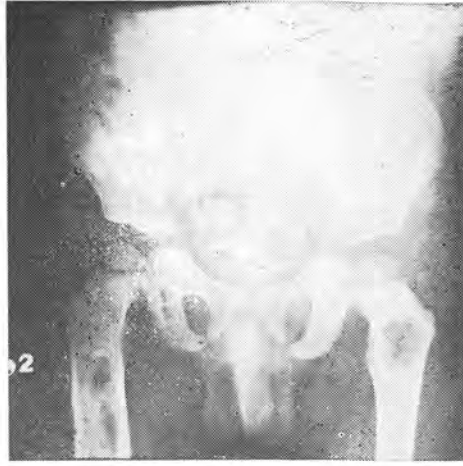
X-ray photos of the pelvic bone, showing the osteolytic lesions (left) which diminished in size after therapy was instituted (right).
